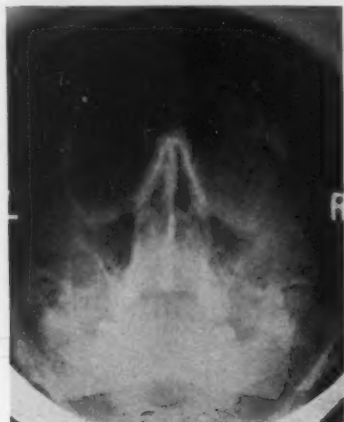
X-ray before operation showing destruction of malar and outer angle of orbit.
